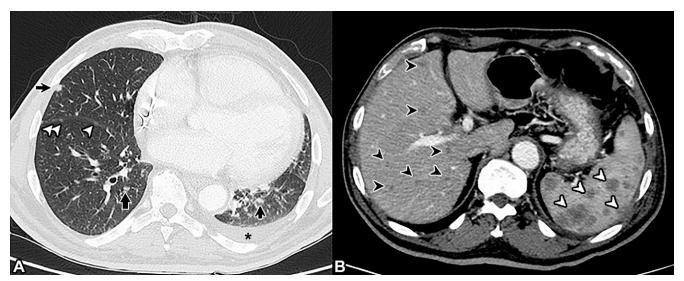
(A) Axial CT scan of the thorax shows perilymphatic micronodules (arrowheads), subpleural and interlobular alveolar opacities (arrows), and mild pleural effusion (*). (B) Axial CT scan after intravenous contrast media administration shows multiple hepatic (black arrowheads) and splenic (white arrowheads) nodules.
